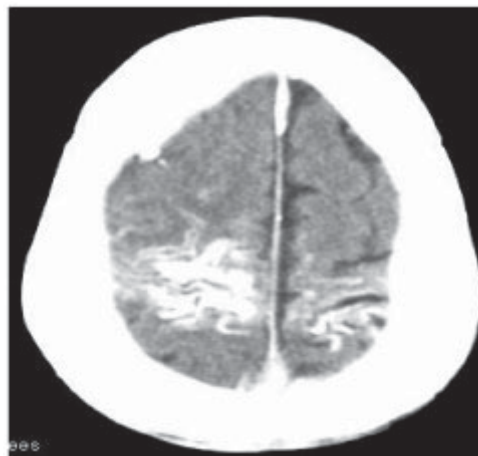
CT scan shows bilateral hyperdense lesions in the temporal and occipital regions.
